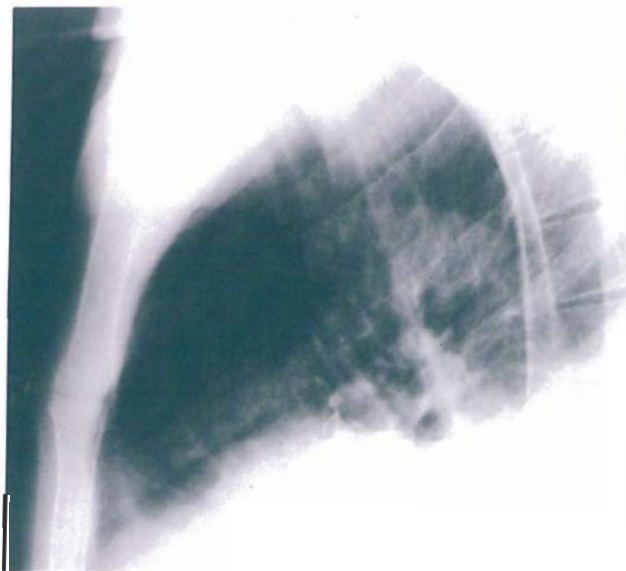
X-ray taken 2 months after Figure A to show the effect of 15 doses of glucose blocking agents and microwaves in clearing the secondary disease from the lung.
